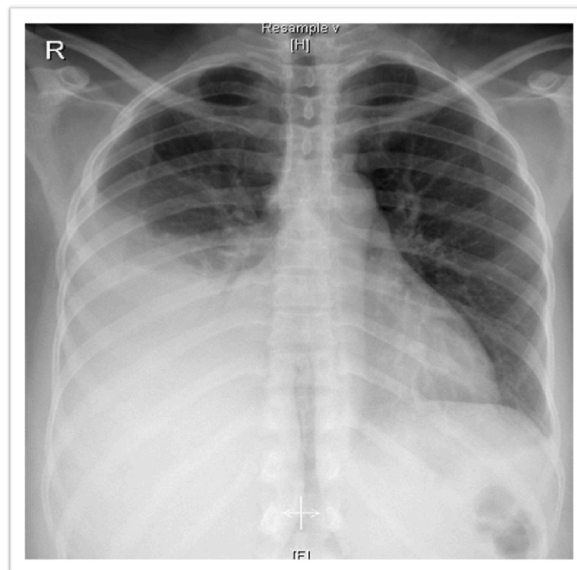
(Follow-up x-ray on day 5th).
